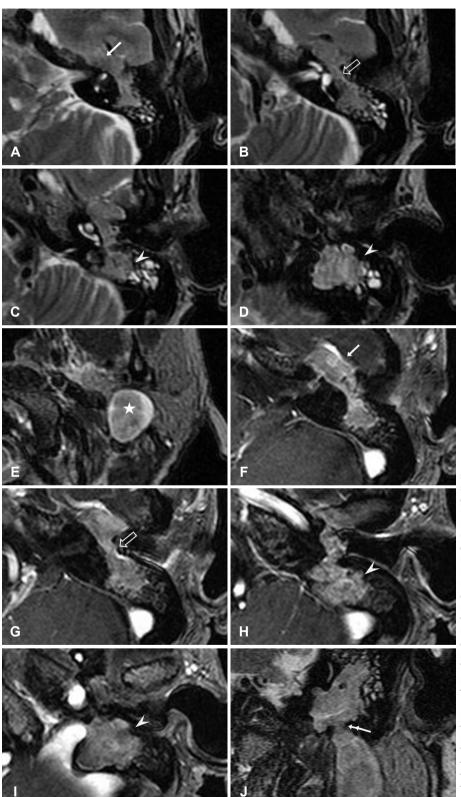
T2-weighted axial images show an expansile homogenous lesion extending from geniculate ganglion (filled arrow)(A) to tympanic (empty arrow) and mastoid (arrow heads) portions of the facial nerve (B, C and D). The extratemporal portion of the tumor (star) appeared benignlooking with a round shape, smooth margins and homogenous enhancement (E). T1-weighted post contrast enhanced axial images showed homogenous enhancement of the distal portion of the intracanalicular and labyrinthine segment and the bulbous enlargement (filled arrow) of the geniculate fossa of the facial nerve (F). The tumor extended along the tympanic segment (empty arrow) of the facial nerve filling the middle ear cavity (G). The tumor in the mastoid segment (arrow heads) appeared multilobulated with irregular margins, mimicking tumor invasion (H and I). A T2-weighted coronal image shows the continuity of the intra- and extratemporal portions of the facial nerve tumor through the stylomastoid foramen (double-headed arrow)(J).
